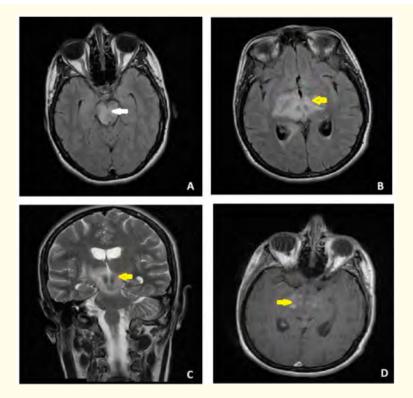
Axial FLAIR sequences (A and B) and coronal T2-weighted (C) imaging demonstrate hyperintensity of the basal ganglia and midbrain (white and yellow arrows). Post-contrast axial T1-weighted imaging (D) shows enhancement, consistent with deep cerebral venous thrombosis.
